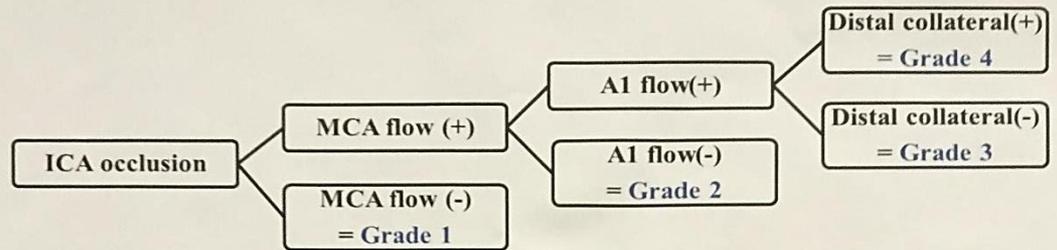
Collateral grades system assessed by CTA in ICA occlusion
